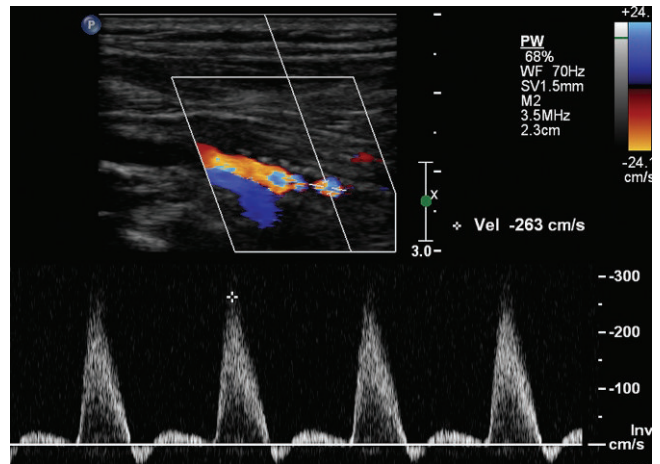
There is aliasing and narrowing in the mid popliteal artery. A spectral Doppler in the narrowing demonstrates increased velocity of 263 cm/s. The peak systolic velocity ratio is 2.4 indicating a stenosis greater than 50%.
